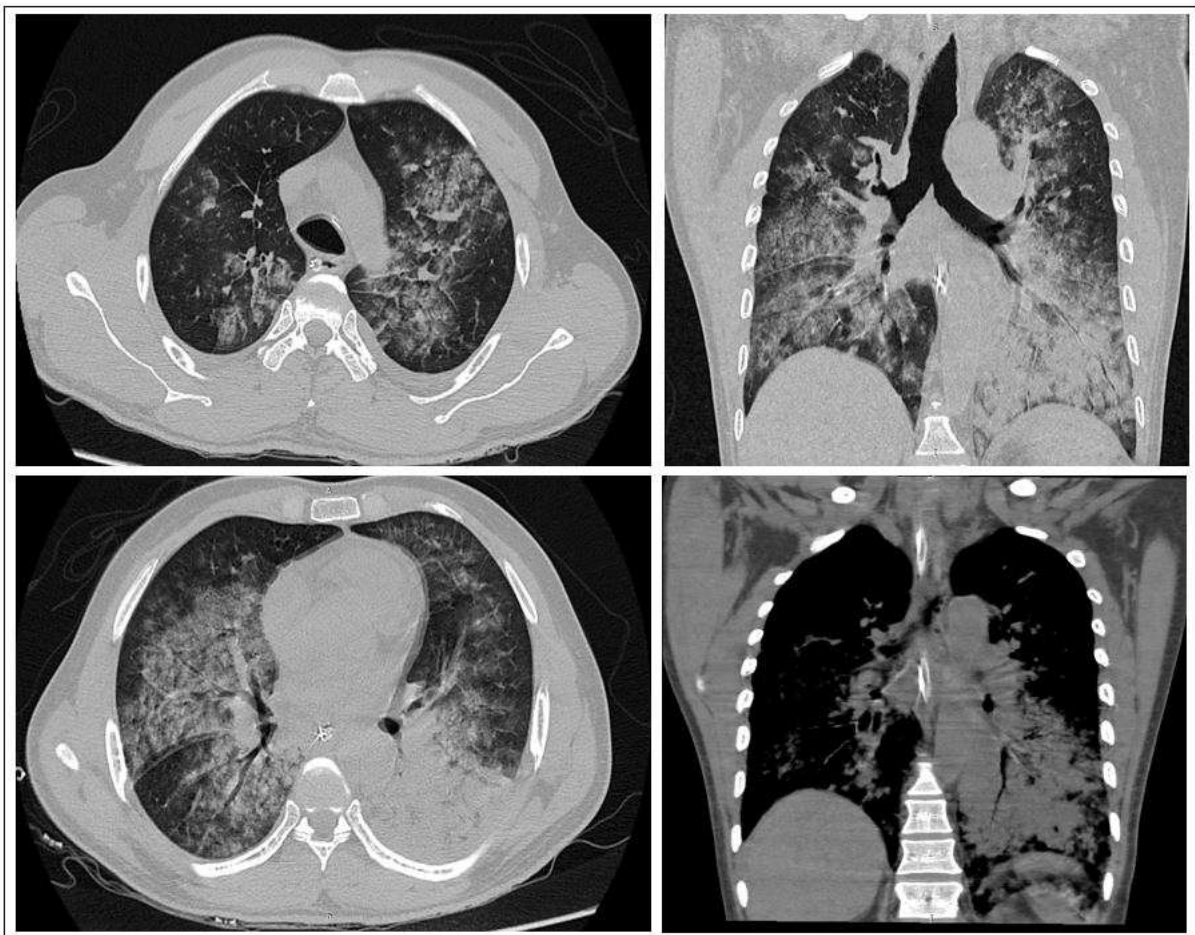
HRCT of chest shows bilateral asymmetric areas of multiple ground glass attenuation and smooth interlobular septal thickening (crazy paving appearance) with an anteroposterior density gradient. Airspace consolidation in left lower lobe.
